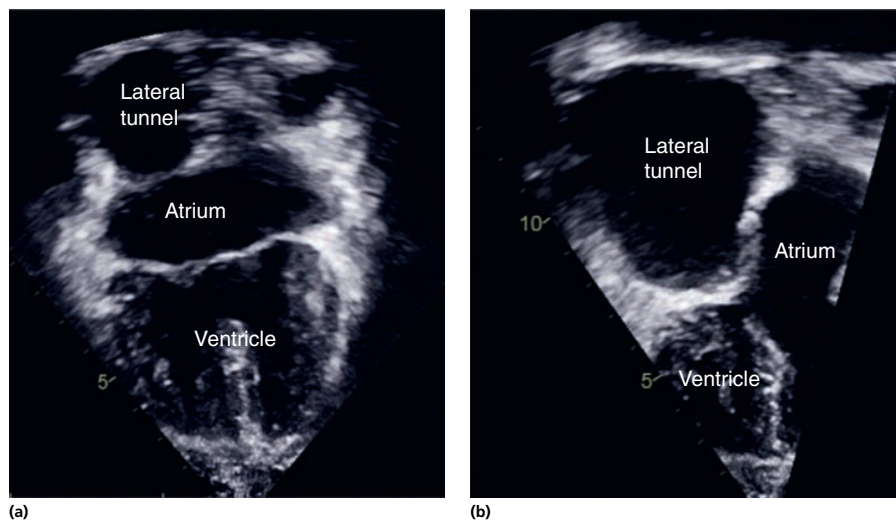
Dilated lateral tunnel. This patient has an intra-atrial tunnel Fontan-type connection. The apical four- (a) and two-chamber (b) views demonstrate the dilated atrial tunnel.
